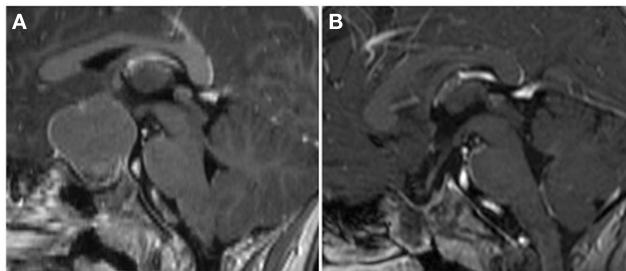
Surgical strategy grade 0/1 pre-op. (A) On the pre-operative MRI, the hypothalamus appeared to be more displaced than invaded by tumor (Type 1 pre-op). (B) This was confirmed during surgery and a complete removal preserving the hypothalamus could be achieved (Type 0 post-op).
